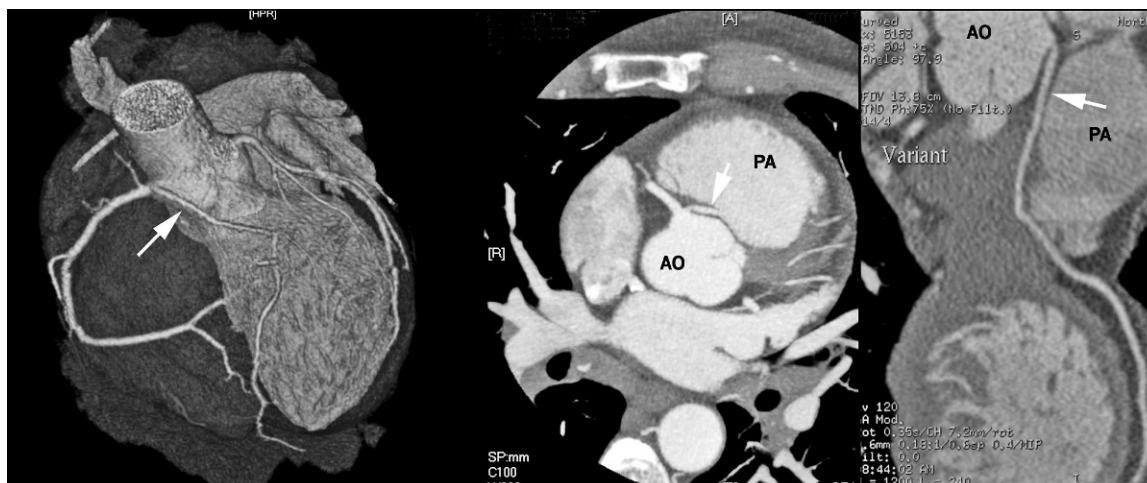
Center: Cardiac computed tomography reveals the anomalous origin of the left anterior descending artery (LAD) from the right coronary sinus (arrow). Left: A volume-rendered image depicts the anomalous LAD. The maximum-intensity projection demonstrates the LAD (arrow) coursing between the aorta and the pulmonary artery. Right: Confirmation of the anomalous coronary. AO=aorta; PA=pulmonary artery
